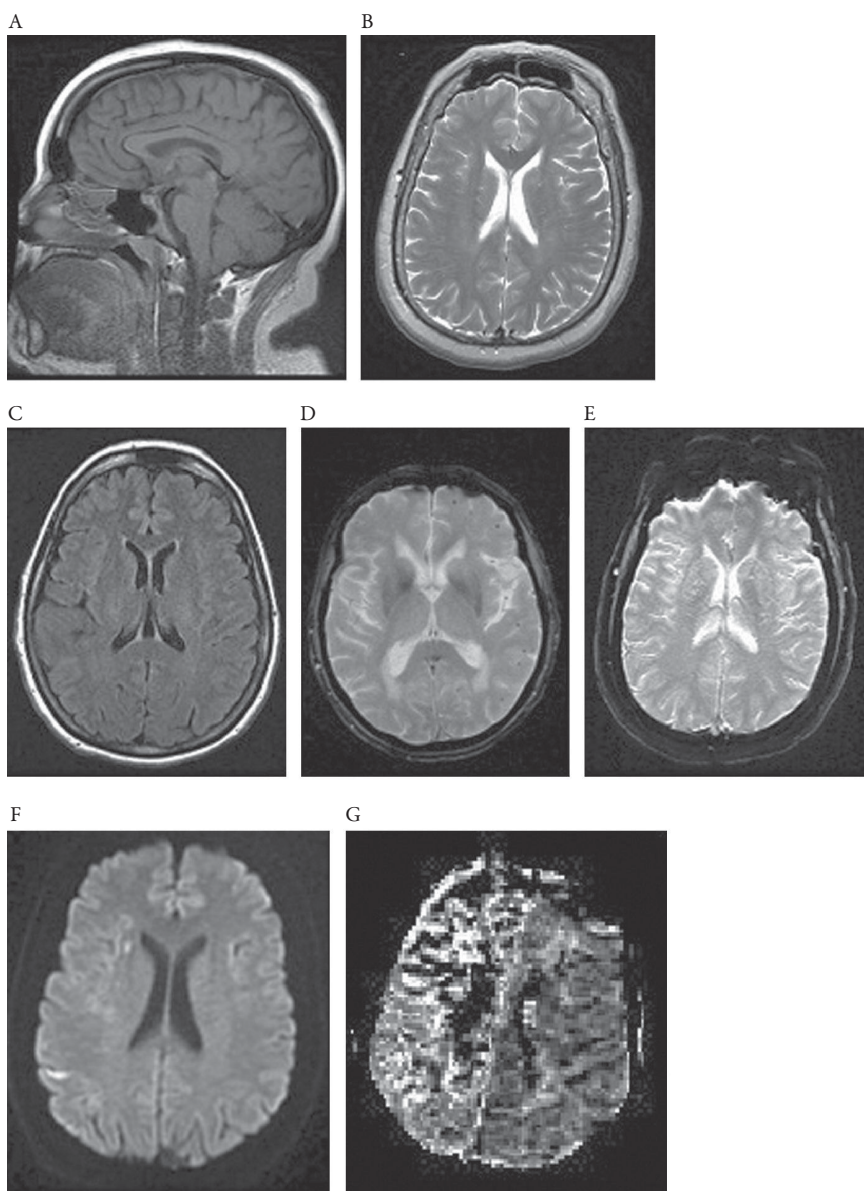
Magnetic resonance imaging sequences used in study of stroke and cerebrovascular disease. (A) Sagittal T1-weighted image. (B) Axial T2-weighted image. (C) Axial fluid-attenuated inversion recovery image. (D) Axial gradient-recalled echo image. (E) Axial susceptibility weighted image. (F) Axial diffusion-weighted image. (G) Axial perfusion-weighted imaging (mean transit time).
